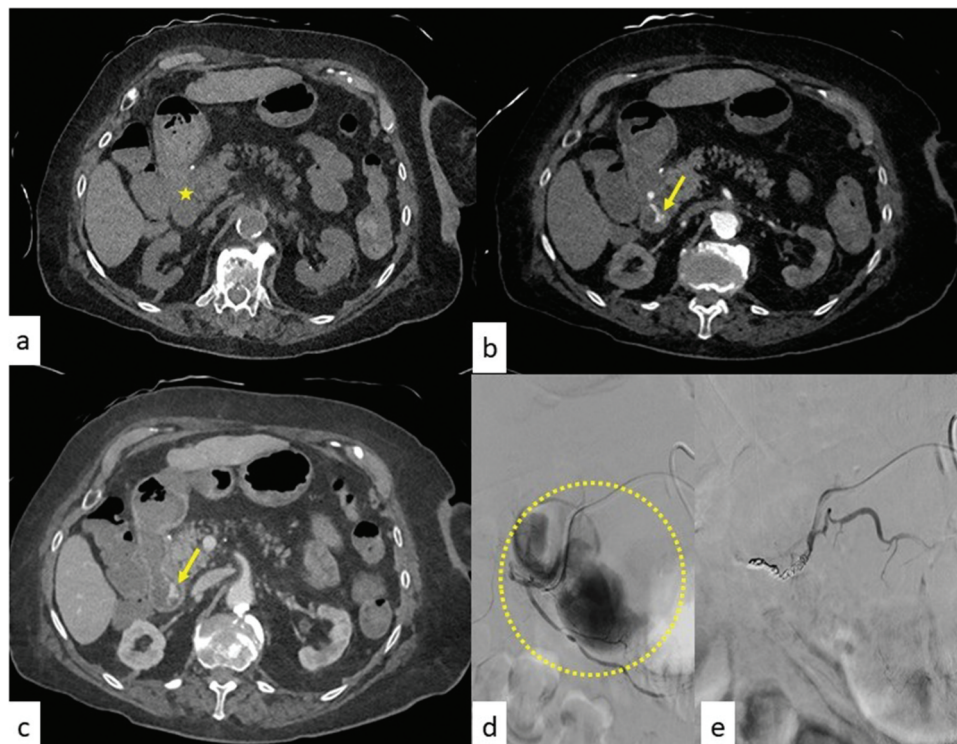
Upfront multidetector-row computed tomography angiography in a patient with clinically severe non-variceal upper gastrointestinal bleeding and a recent history of subtotal gastrectomy. The pre-contrast phase (a) demonstrates a spontaneously hyperdense intraluminal area in the stomach and duodenum (star), consistent with a sentinel clot. In the arterial phase (b), a giant pseudoaneurysm is revealed at the surgical site (arrow), with a massive increase of contrast blush in the venous phase (c, arrow). Coronal maximum intensity projection highlights the vascular anatomy of the pseudoaneurysm arising from the gastroduodenal artery (d, dashed circle). These findings are consistent with those obtained from the subsequent operative angiography (e, dashed circle), before embolization (f). Informed patient consent was provided for the publication of these images.
